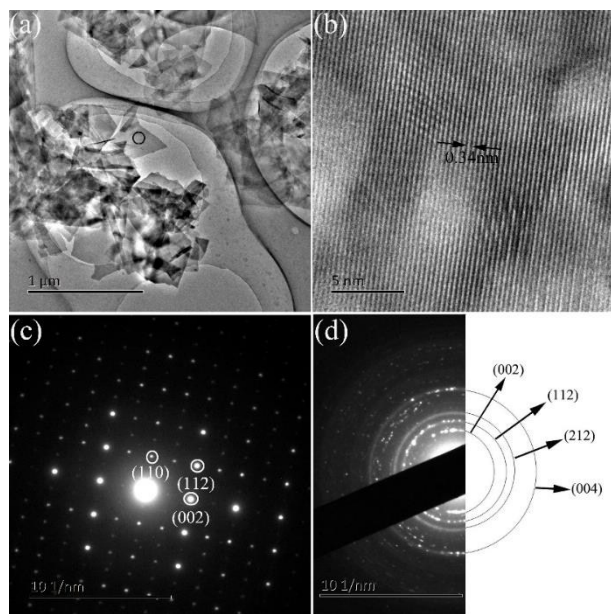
TEM images of the as-obtained CHA synthesized at 180°C for 0.5 h (a) A typical image of the microsphere after ultrasound treatment, (b) the corresponding high resolution image and (c, d) the SAED pattern.
